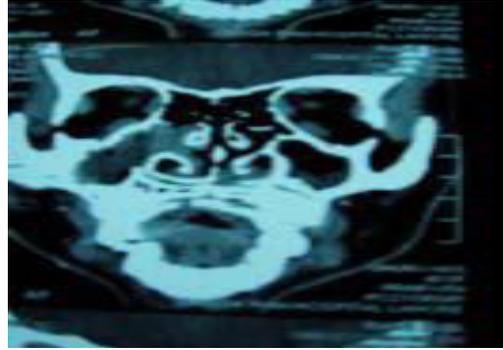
CT of same patient
